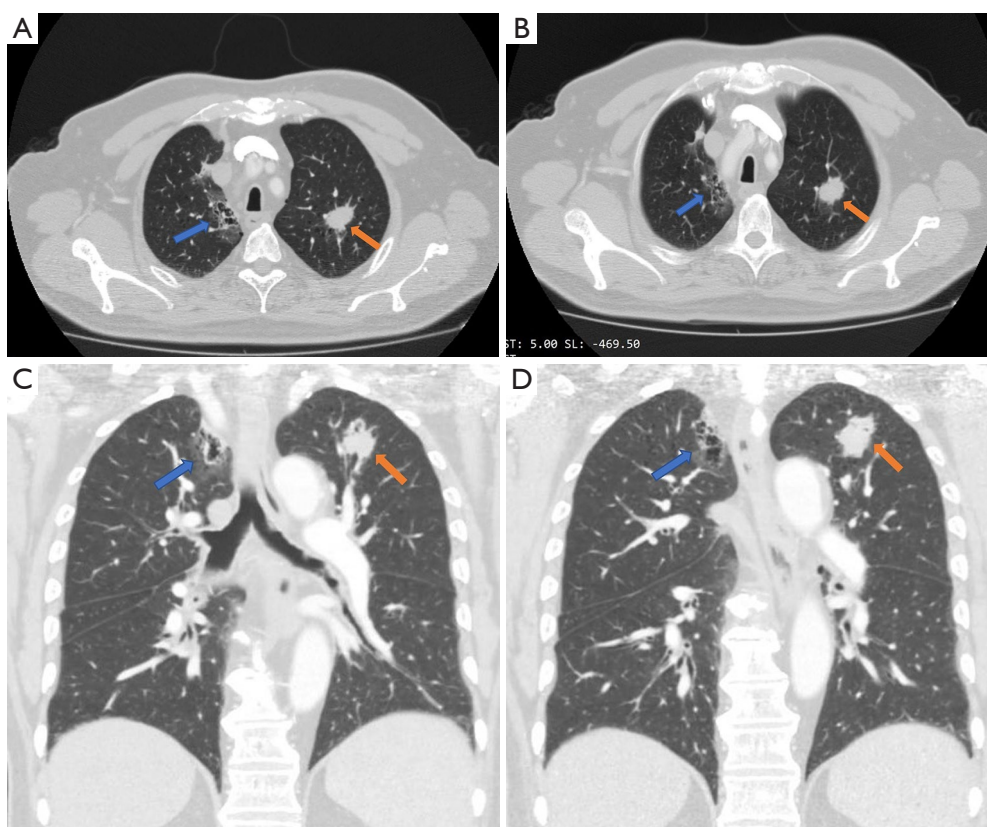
Computed tomography (CT) images. The blue arrow indicates the location of the right lung mass, and the orange arrow shows the left lung mass. The left solid lung cancer exhibits multiple burrs in the transverse axial view, and the right lung cancer has a cystic airspace in the transverse axial view at different levels (A,B). Lesions in both lungs are visible on different reconstructed coronal planes (C,D).
